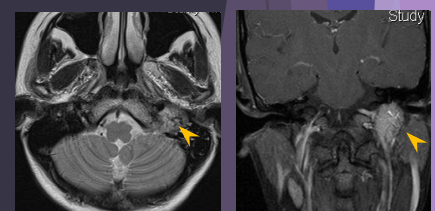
MRI T2 axial (Left) & T1 + C cor (Right)
